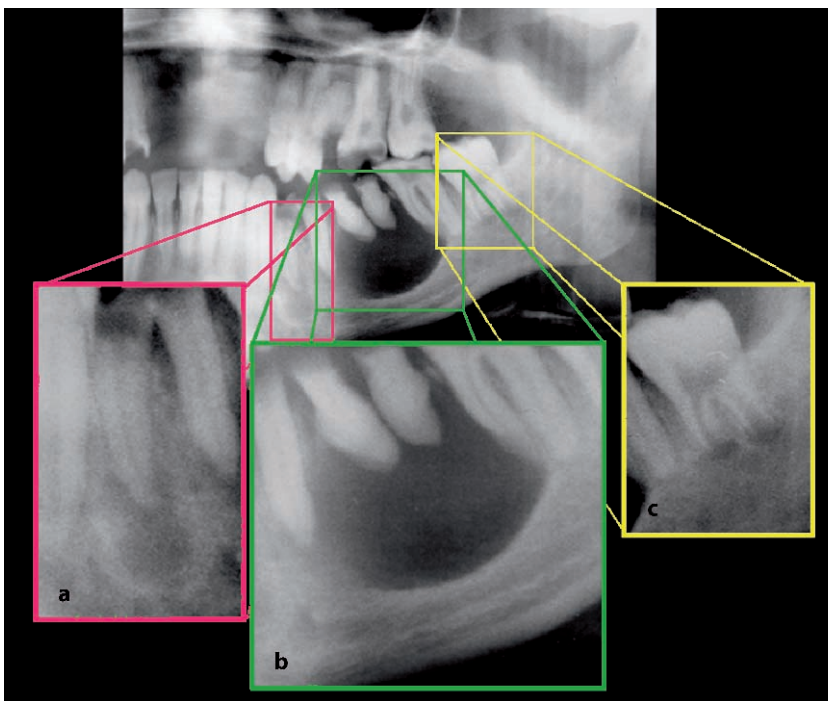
Details of panoramic radiograph showing moderate (a) and large (b) periapical radiolucencies, and normal tooth development (c) where the root apices have not fully formed
